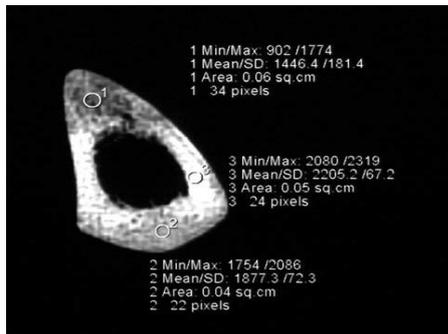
Example of a 20-year-old male runner with medial tibial stress syndrome. CT measurements demonstrate normal medial cortex and osteopenic anterior and posterior cortices [8].
